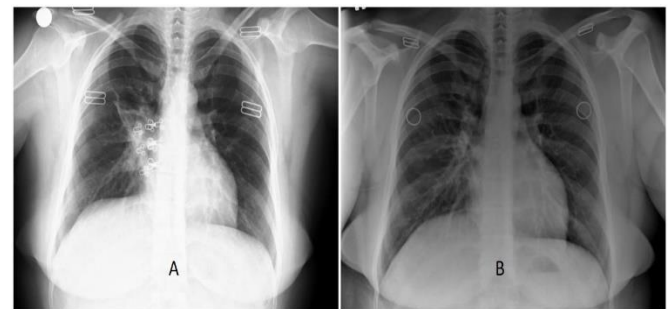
The chest radiograph; A: at the end of the treatment (after 6 weeks), B: after one year
